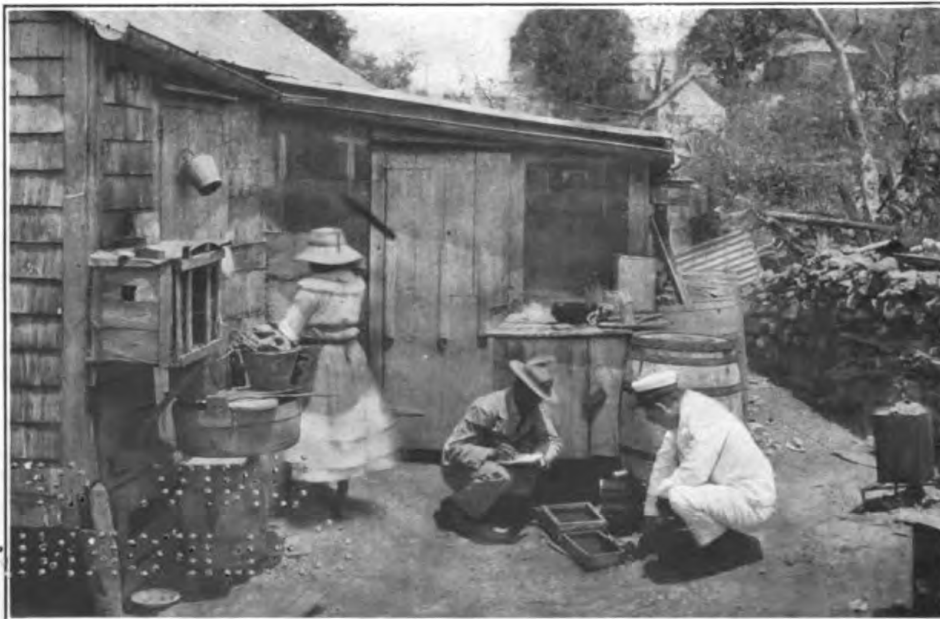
CHIEF PHARMACIST'S MATE INSPECTING PREMISES FOR MOSQUITO LARVÆ IN ST. THOMAS, VIRGIN ISLANDS
